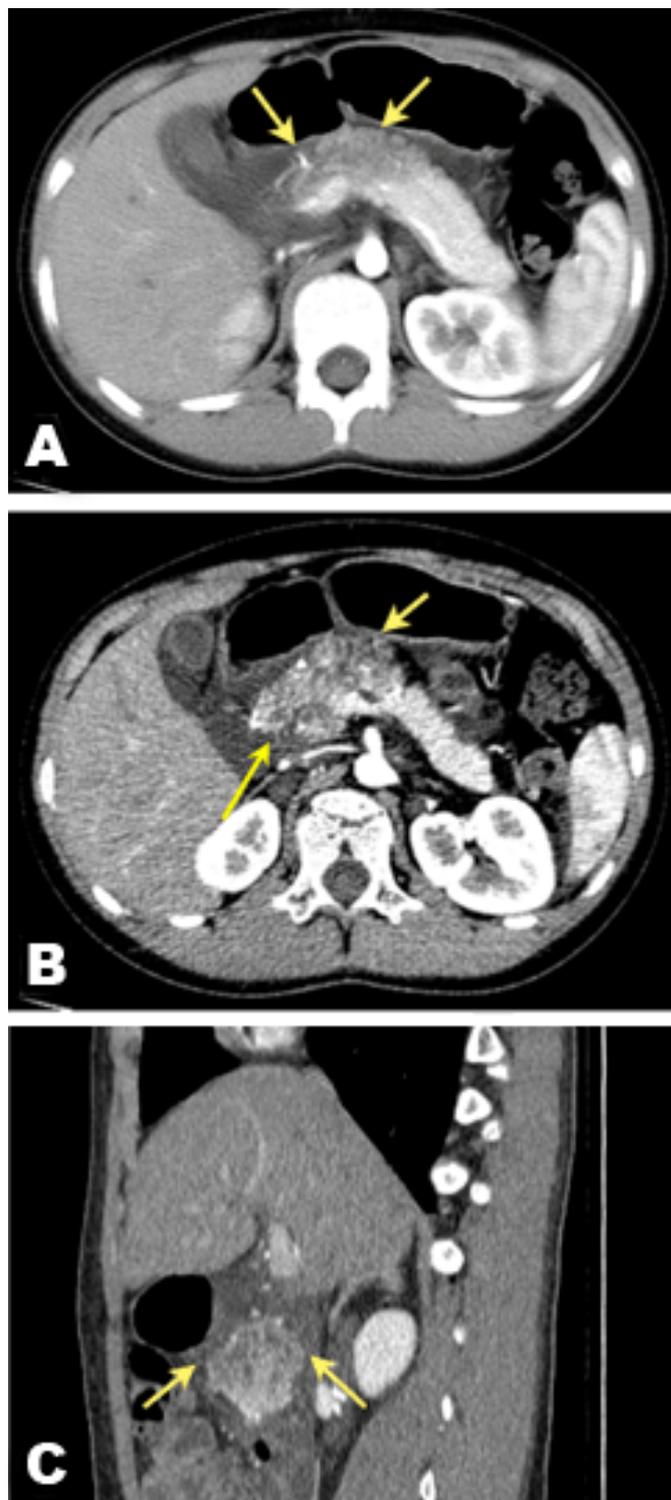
Suspected cystic mass in the pancreatic head and neck as seen on computed tomography scans (Yellow arrows, suspected cystic mass). Axial CT with no enhancement (A) or with two-phase contrast, (B) exhibiting an interconnecting cysts separated by septa in the pancreatic head and neck. Reconstruction in sagittal projection, and arterial phase demonstrating poor enhancement of the lesion (C).
